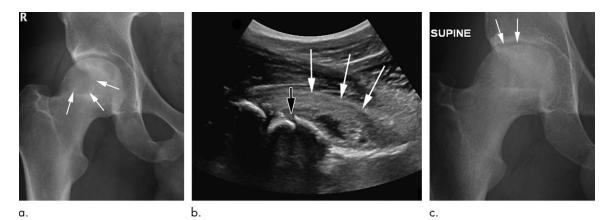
Osteonecrosis in a 29-year-old man who presented with right hip pain. (a) Anteroposterior radiograph of the pelvis shows osteonecrosis in the right femoral head, with preserved femoral head contours (arrows). He subsequently went to the sports medicine clinic and received a right hip joint corticosteroid injection for pain. (b) Three months later, he was referred to our institution for repeat intra-articular corticosteroid injection. The patient presented with a severe limp when walking and described the pain as worse than his original pain. Preprocedural sagittal US image shows a defect in the anterior right femoral head cortex (black arrow) and moderate joint effusion with a severely thickened anterior joint capsule (white arrows). The intra-articular corticosteroid injection was cancelled given the US findings, and the referring orthopedic physician was informed of the findings. (c) Repeat anteroposterior right hip radiograph obtained 1 week after US when the patient was seen in the orthopedic clinic for a follow-up visit enabled confirmation that the superior femoral head articular surface had collapsed (arrows), and the patient underwent right hip joint replacement.
